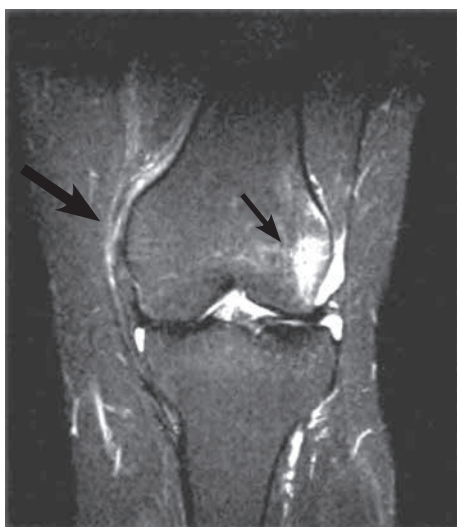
MRI study of the left knee reveals complete rupture of the sMCL and dMCL from the femur (large arrow). Bone bruise can be noted on the lateral femoral condyle, suggesting a valgus mechanism (small arrow).
